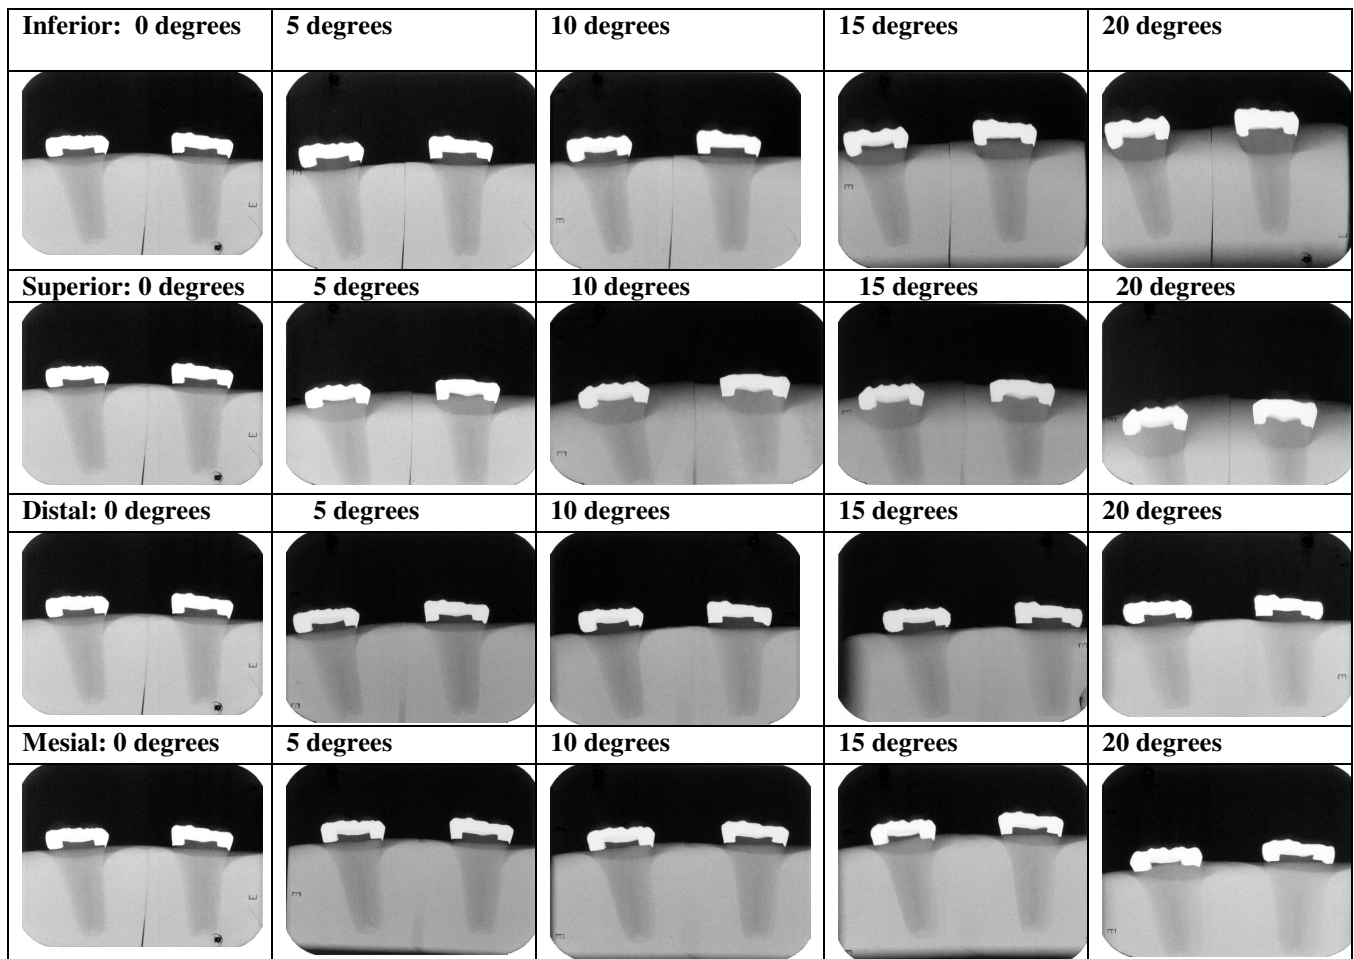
Two amalgam restorations radiographed at 5 to 20 degrees from the right angle of the 'bitewing' radiograph 0-Degrees.
